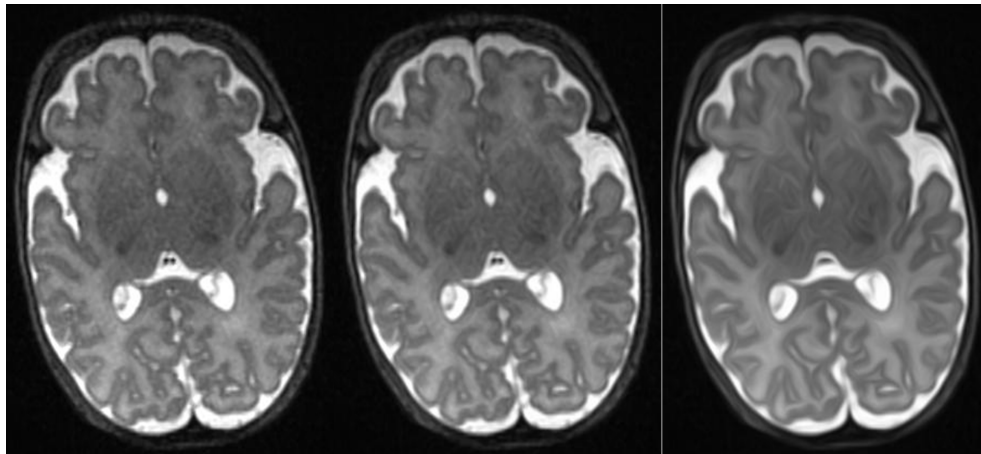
The left image shows an example of the original MR image, the other images are results after applying the CED filter using different diffusion parameters; second image: $t=1$; third image: $t=10$.
